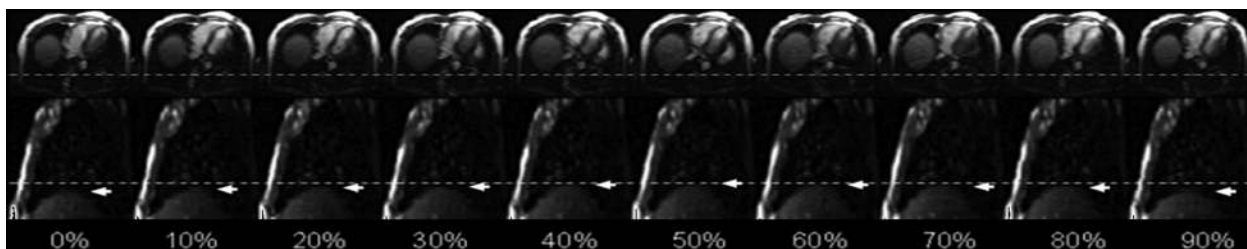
Representative 4D-MRI images of Subject #2. Dash lines are drawn to facilitate the visualization of the respiratory motion. Arrows indicate the tracking point (diaphragm) that was selected to generate the motion trajectory.
